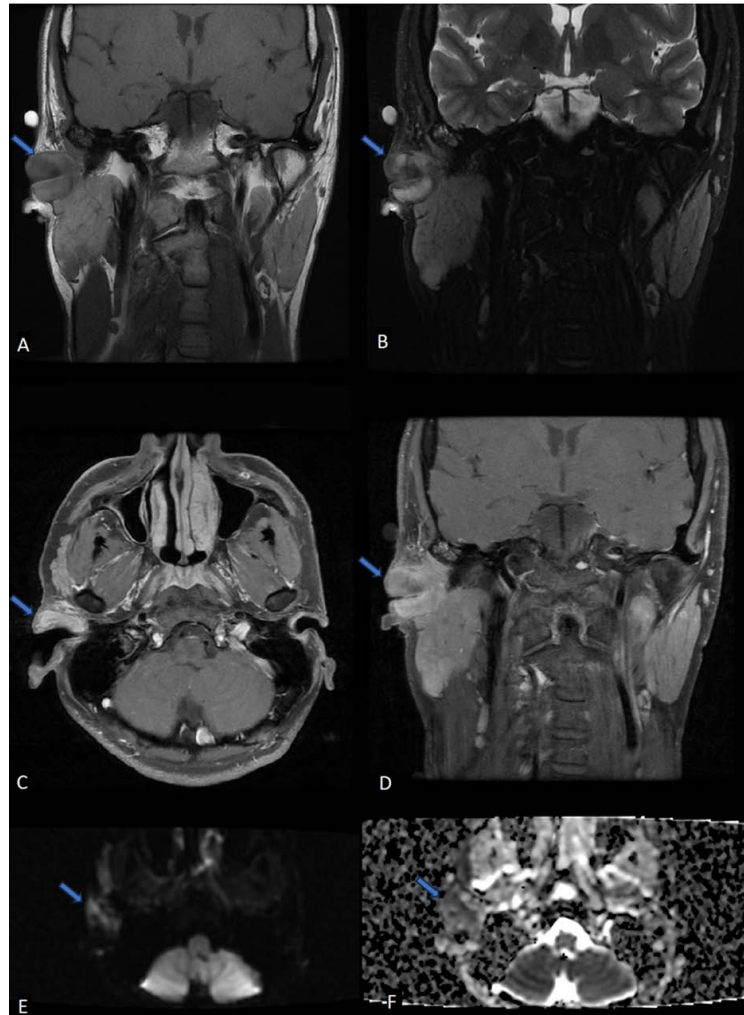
Findings: MRI performed showed circumferential thickening of the right EAM (blue arrow). (A) T1-weighted coronal demonstrating isointense signal; (B) T2-weighted fat saturated coronal demonstrating iso-hyperintense signal; (C) axial post IV-gadolinium contrast T1-weighted fat-saturated shows homogenous enhancement; (D) coronal post IV-gadolinium T1-weighted fat-saturated shows homogenous enhancement; (E) DWI and (F) ADC demonstrating minimal diffusion restriction. *TECHNIQUE:* 3.0T GE Discovery MR 750W; T1w (TE: 12.9, TR: 619.0); T2-fat saturated (TE: 94.1, TR 3482.0); T1w post contrast (TE: 9.9, TR: 833.0); DWI & ADC (TE: 64.9, TR: 3200.0).
